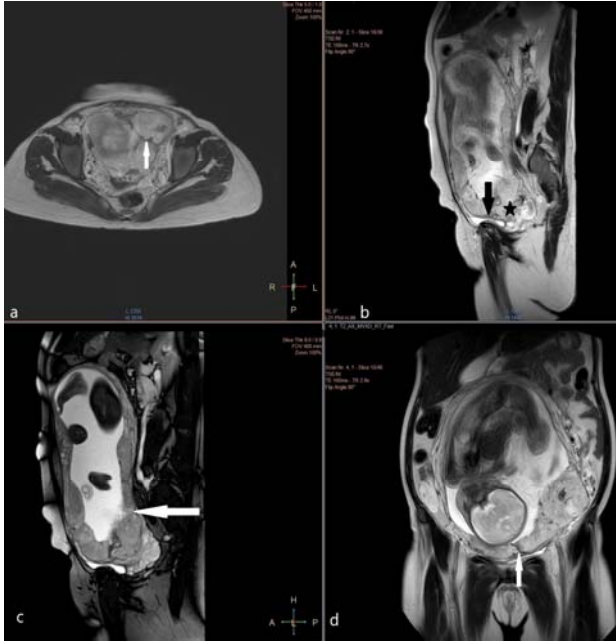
Axial T2-weighted (a) showing; Intraplacental dark band (white arrow) with the major diameter longer than 2 cm. Sagittal T2-weighted (b) showing; Percreta signs: direct invasion (dark arrow) of bladder, Placental protrusion sign: the placenta extends and projects (dark asterisk) into the internal uterine os. Sagittal T2-BTFFE image showing: (c) and coronal T2-weighted (d) images showing; Placental recess: the contraction of the placental surface accompanying a dark band (white arrow).
